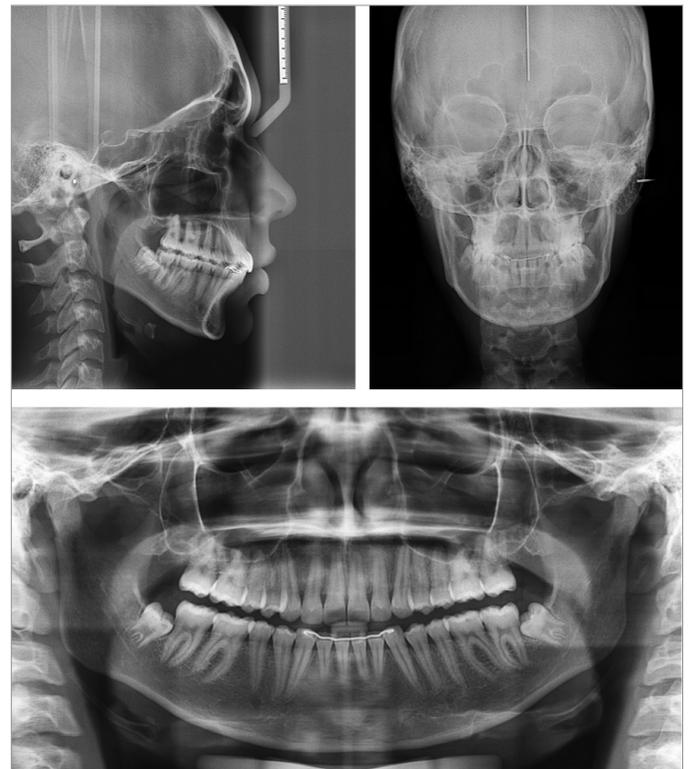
Post-treatment lateral and posteroanterior cephalometric and panoramic radiographs
